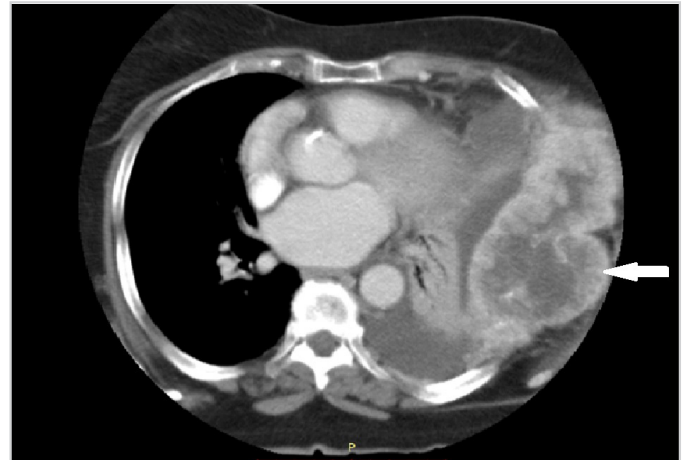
Papillary carcinoma of thyroid with follicular variant. CT of thorax showing the destructive lesion in left lower rib cage with large soft tissue component measuring 13.3 x 6.5 cm (arrow)
